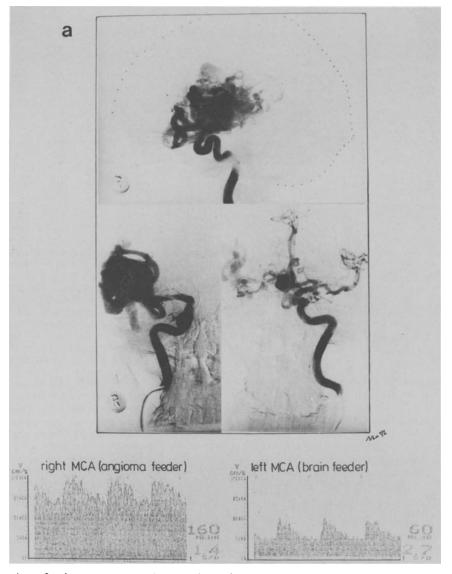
Large angioma of right sylvian fissure, ACommA aneurysm. <u>a Transcranial Doppler patterns showing high flow velocities in feeding</u> right MCA compared to normal findings in left MCA (Fig. 2b see p. 114)
